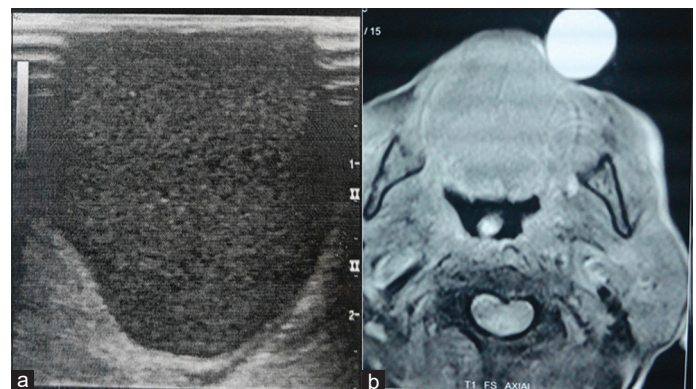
(a) Thin-walled spherical cystic lesion showing homogenous internal echoes in an ultrasound; (b) magnetic resonance imaging showing T2 fat sat homogenously hyperintense
